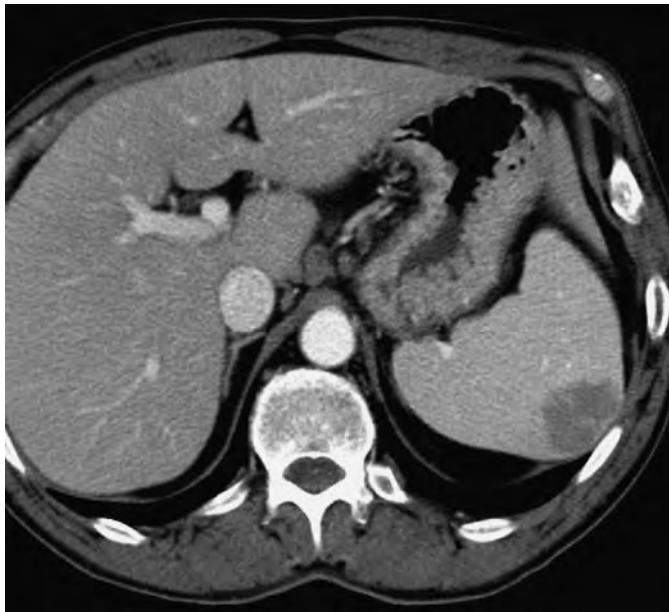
Splenic metastasis from lung cancer. The enhanced CT scan of the upper abdomen during the portal venous phase reveals an ill-defined, hypodense mass in the spleen 6 months after resection of a lung cancer (i.e., confirmed squamous cell cancer).
